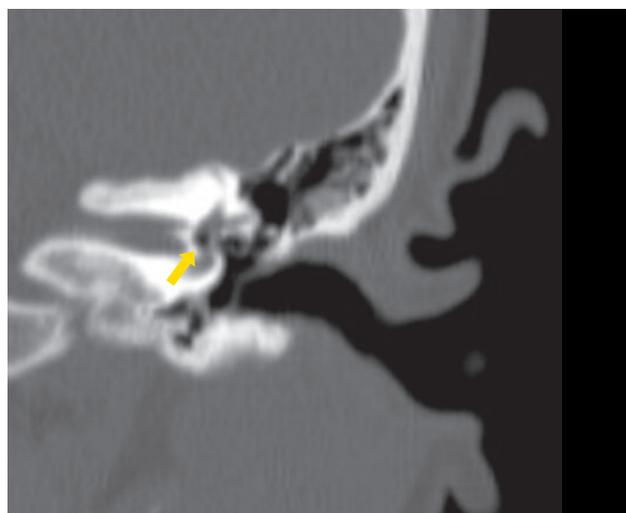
Coronal computed tomography image of the temporal bone shows the same air bubble in the left vestibule (arrow)
